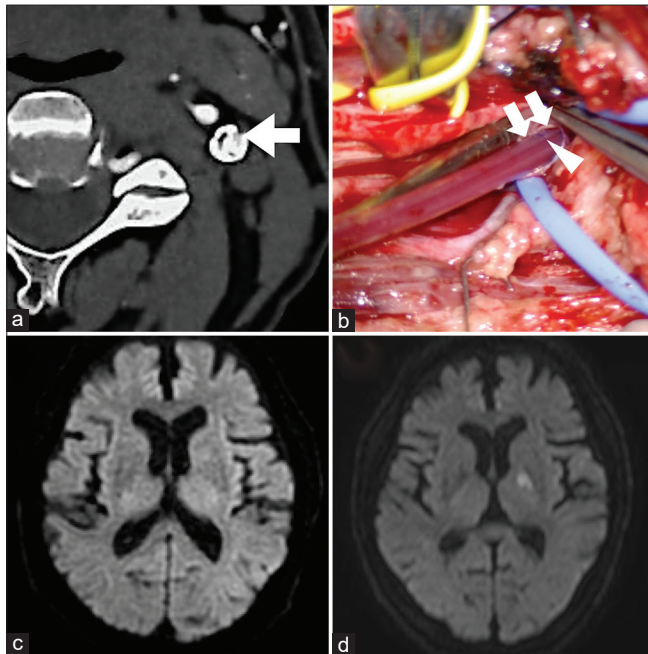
(a) Computed tomography angiography showed internal carotid artery (ICA) stenosis with marked calcification. The arrow indicates the narrowed inner lumen of ICA. (b) After endarterectomy. Arrow head shows the marker of the internal shunt which is 3 centimeters apart from the end. Double arrows show the edge of the intima. (c) No new cerebral infarction was confirmed by brain MRI on POD 1. (d) On POD 7, the patient developed dysarthria and right-sided hemiplegia. Brain MRI showed acute infarction at the left posterior limb of internal capsule.
